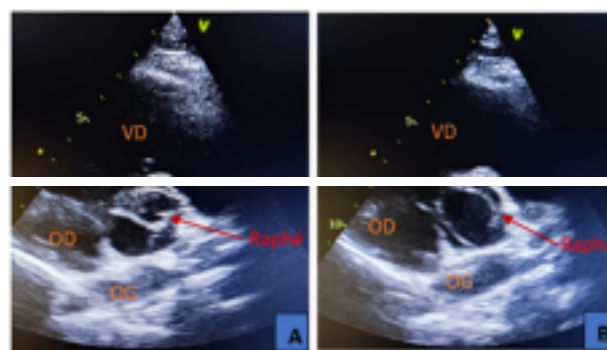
Transthoracic echocardiography image, in short-axis para-sternal incidence, showing type 1 L-R aortic bicuspid aortic valve of case N°1 in closed position (A) and in open position (B).
